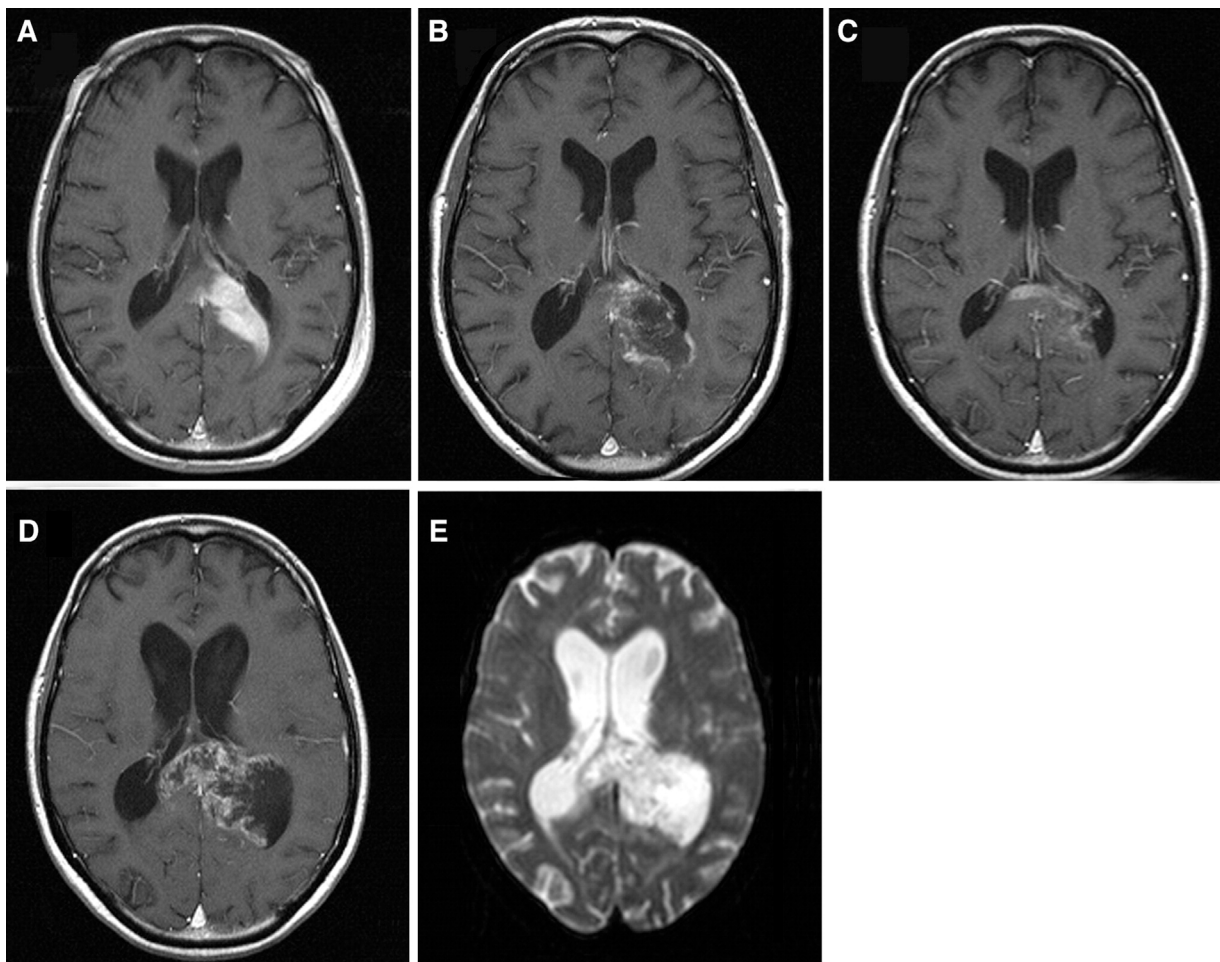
MRI Demonstrating Evolution of GBM to Radiation Necrosis.
